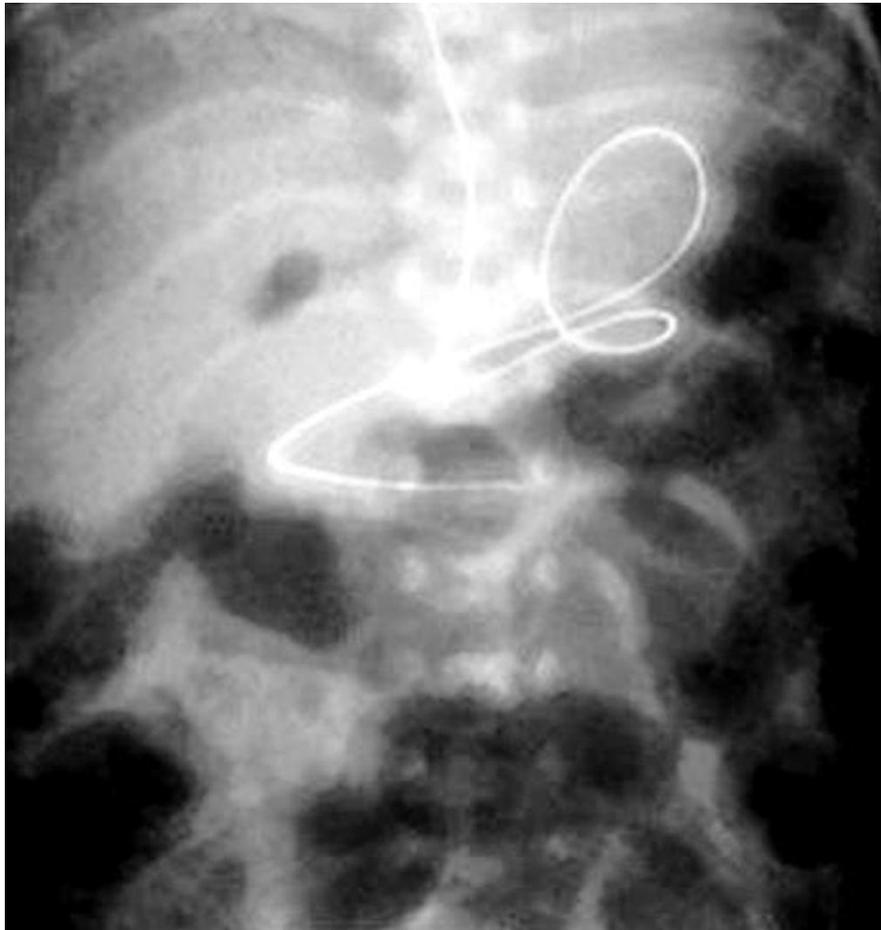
Antero-posterior roentgenogram of an abdomen of an infant with necrotizing entero-colitis showing dilated large and small intestine with pneumatosis intestinalis. Note small air bubbles and linear gas shadows in the bowel wall.
